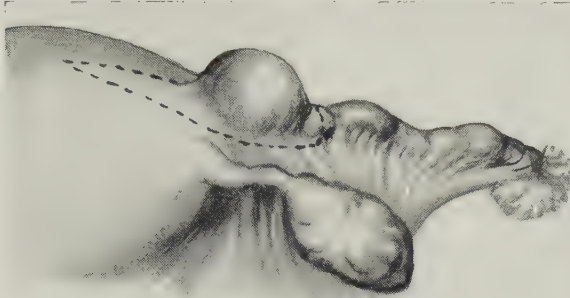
UTEROSALPINGOSTOMY FOLLOWING PARTIAL SALPINGECTOMY OF THE INNER ASPECT OF THE TUBE — I; — Excising the inner end of the tube and a transverse wedge-shaped section of the horn of the uterus.
